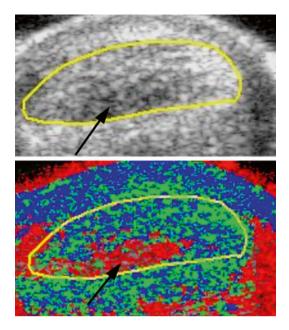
Patellar tendinopathy studied with highdefinition colour Doppler ultrasound. Comparison between right and left patellar tendons. Longitudinal view reveals intensive thickening (11 mm vs. 3.9 mm) combined with hypoechoic zones
